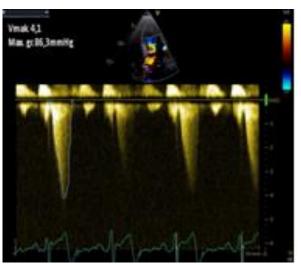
CW Doppler with sample volume at LVOT which shows LVOT maximum velocity 4,1 m/s with "dagger-shaped" envelope and peak pressure gradient of 86,3 mmHg.
